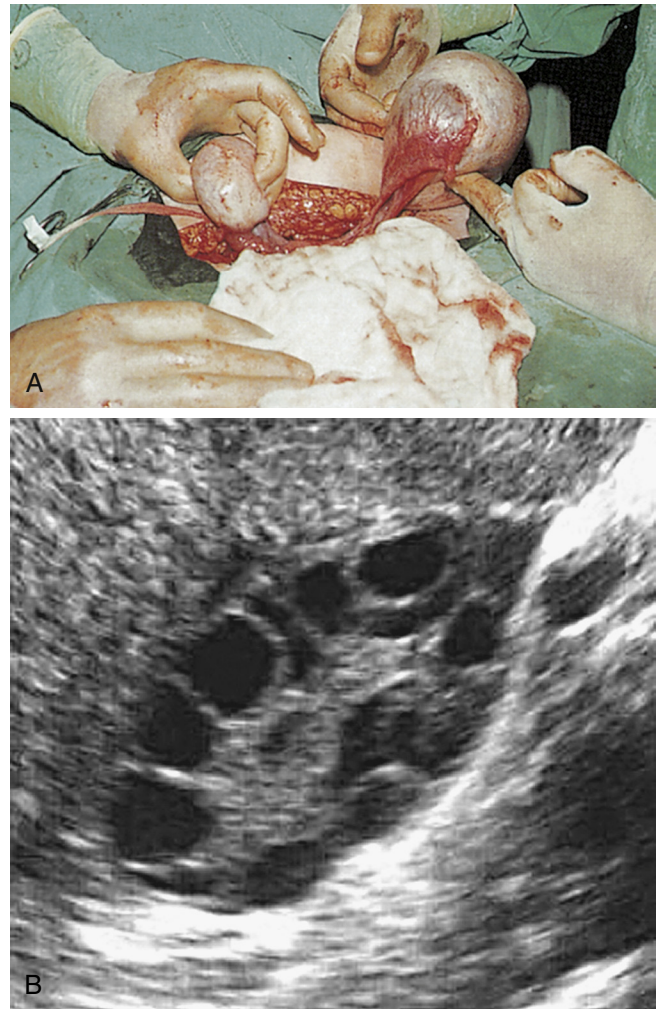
Polycystic Ovary. A, Surgical view of polycystic ovaries. B, Ultrasound of polycystic ovary. (A from Symonds EM, Macpherson MBA: *Diagnosis in color: obstetrics and gynecology*, London, 1997, Mosby-Wolfe. B from King J: *J Midwifery Womens Health* 51[6]:415–422, 2006. Reprinted with permission.)
